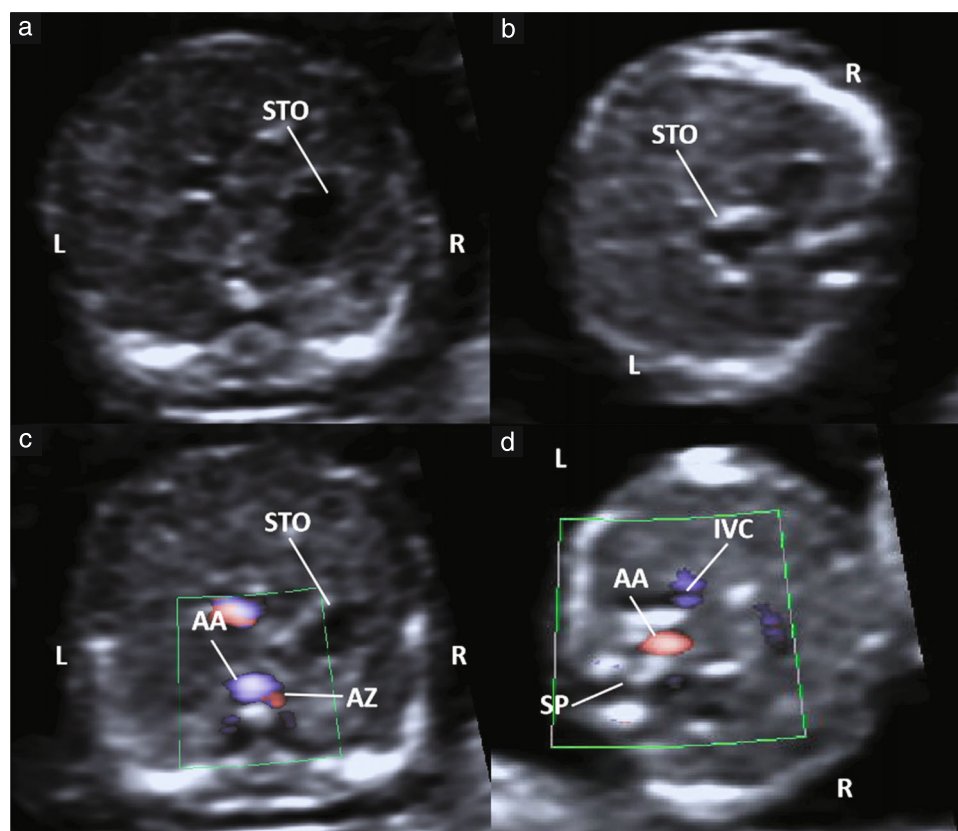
Grayscale and color Doppler ultrasound images in first trimester, showing: (a) fetal stomach (STO) on right; (b) fetal STO on midline; (c) inferior vena cava disconnection and azygos vein (AZ) dilation; (d) abdominal aorta (AA) and inferior vena cava, both located on left side of spine (SP). IVC, inferior vena cava; L, left; R, right.
